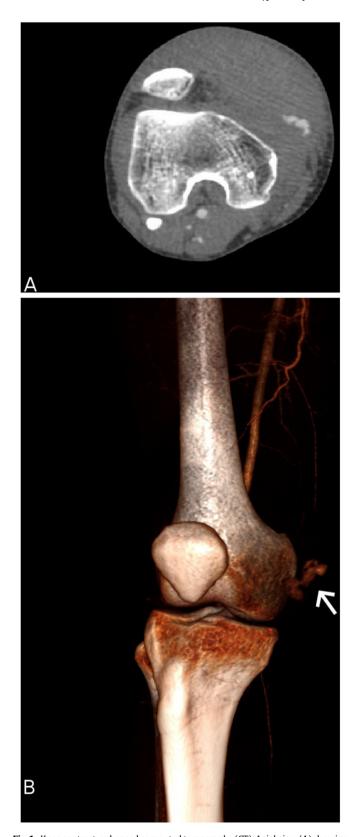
Knee contrast-enhanced computed tomography (CT). Axial view (A) showing a large haematoma in the medial side of the knee. 3D CT reconstruction (B) revealingactive bleeding (arrow) from the descending genicular artery (DGA).
